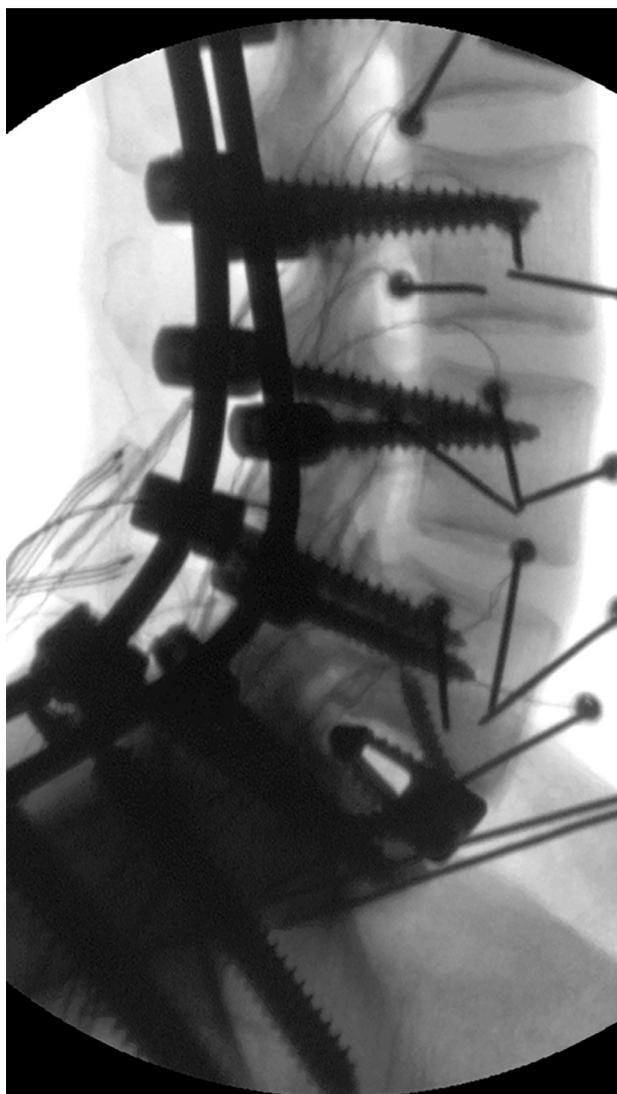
Postinstrumentation lateral radiograph of lumbo-sacral ALIF construct. Used with permission from [blinded for review]. ALIF, anterior lumbar interbody fusion.
